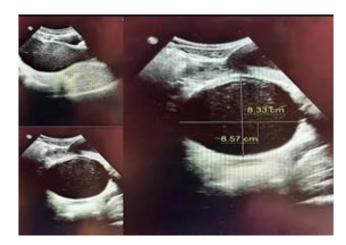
Ultrasound findings shows a mass effect on the bladder refers to hematocolpos.
